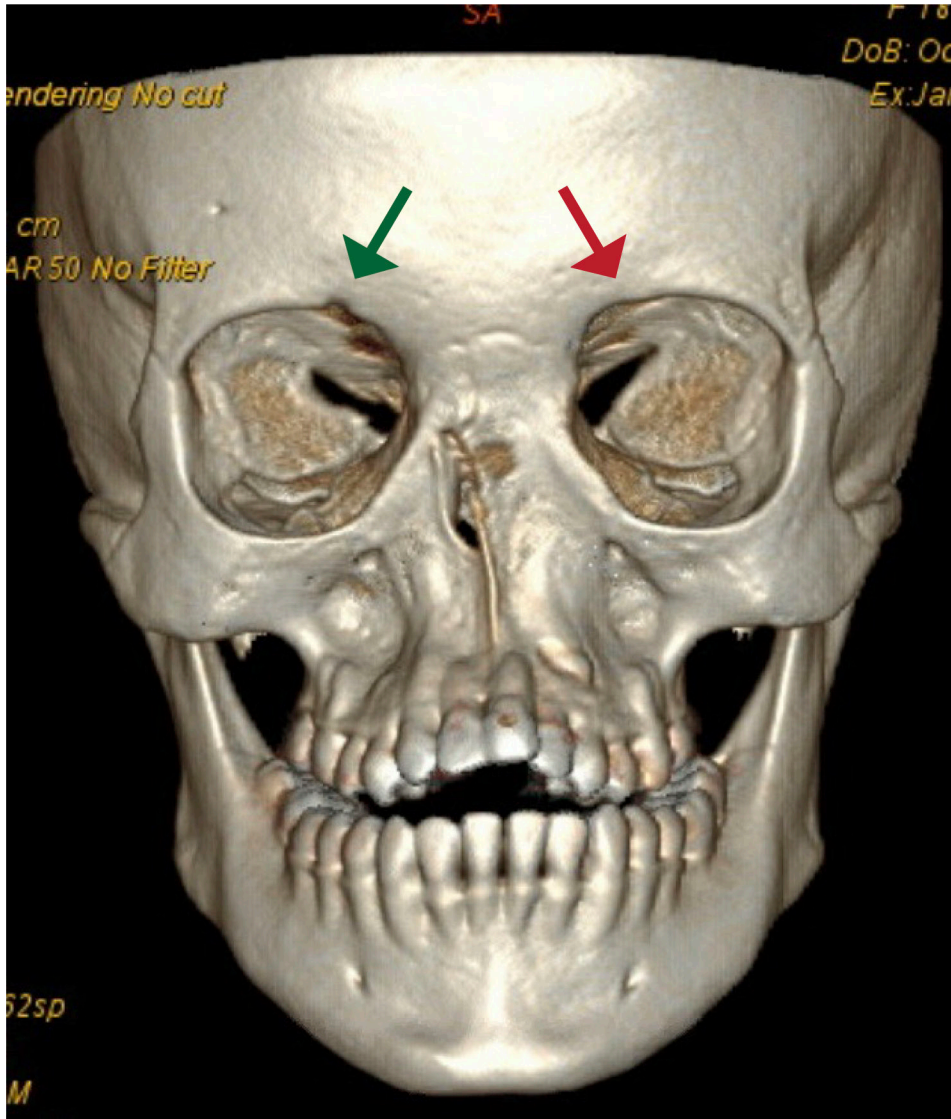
Pre-operative CT image of Subject I showing the supratrochlear foramen present on the right (green arrow) and absent on the left side (red arrow).
